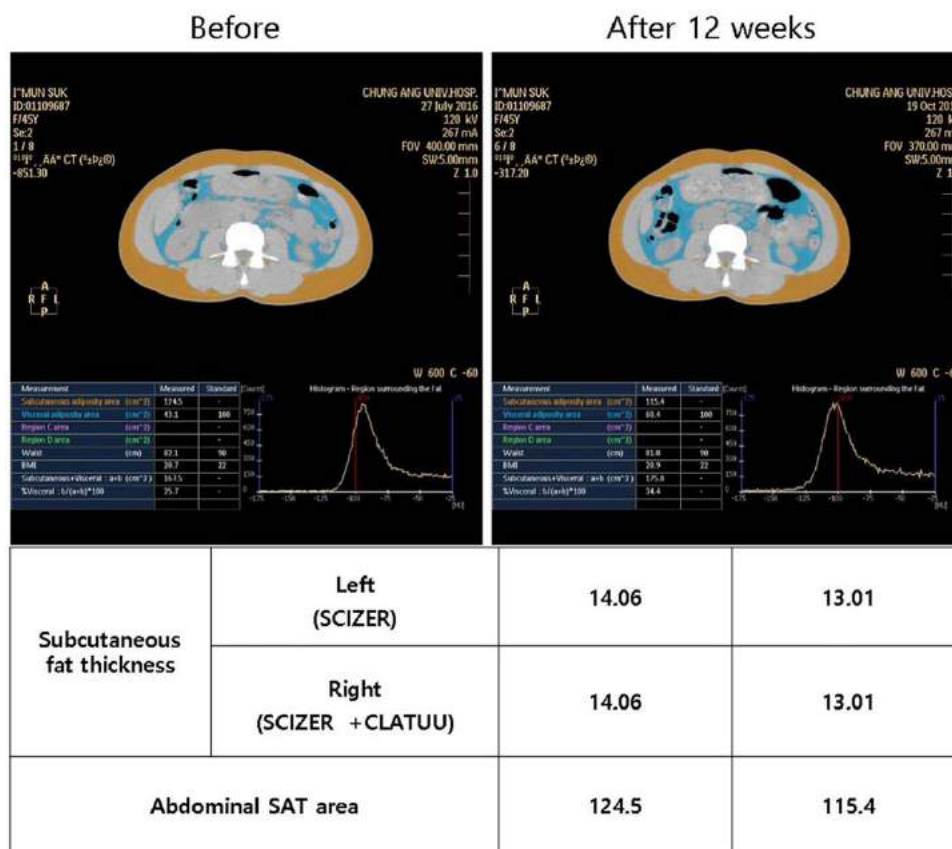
Subcutaneous adipose tissue (SAT) area and fat thickness by Fat CT in case 2
